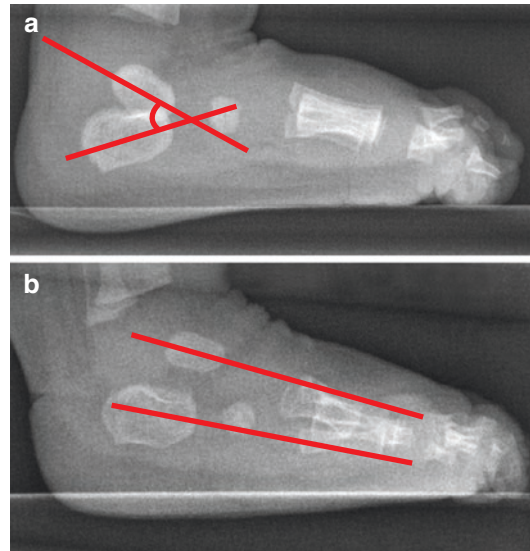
Lateral X-ray. (a) This is a normal foot with a normal angle between the talus and calcaneus. (b) Clubfoot, the longitudinal axis of the talus and calcaneus on the right side are almost parallel
